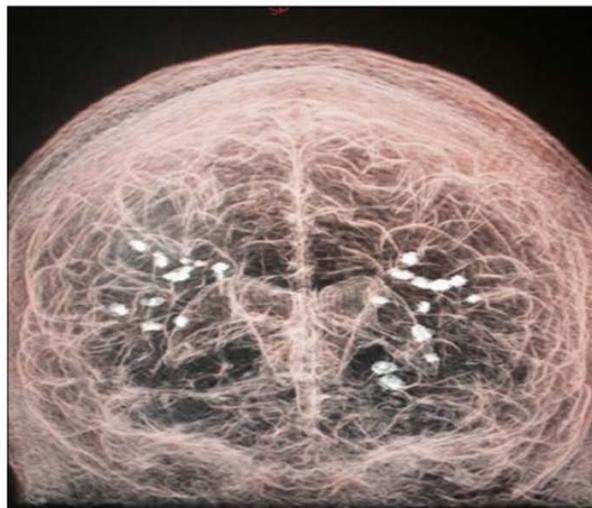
Example of brain Focal Cerebral Microangiopathic Lesions (white spots) in 3D MRI reconstruction.
